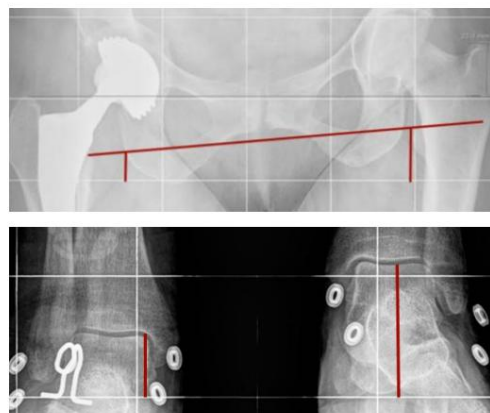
MMII telemetry and AP pelvis X-ray: we found a 14mm structural elongation with an 8mm offset increase and a 70° vertical cup.
